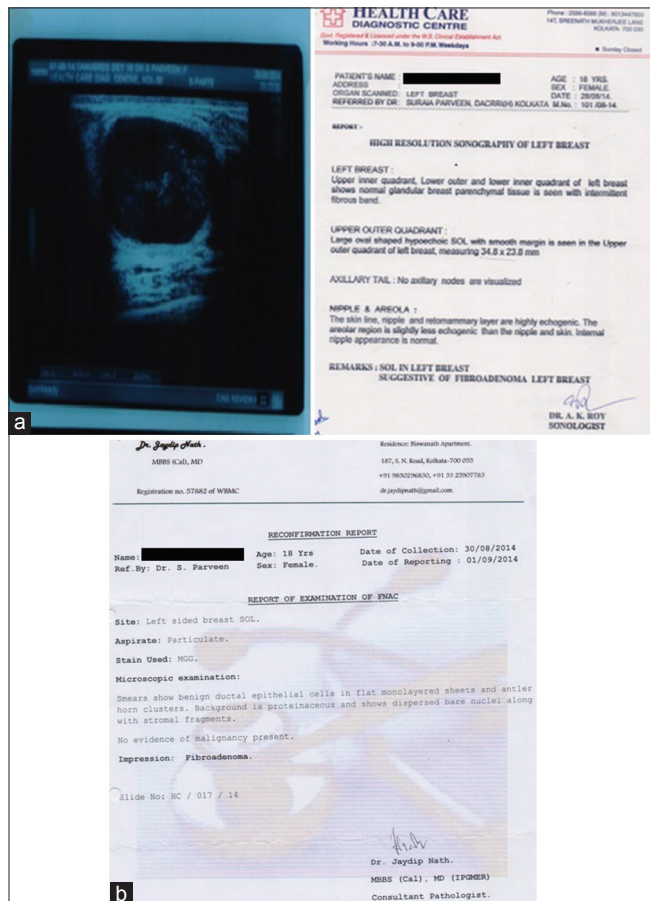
(a) Ultrasonography report of the left breast on August 28, 2014 (baseline), (b) fine-needle aspiration cytology report
